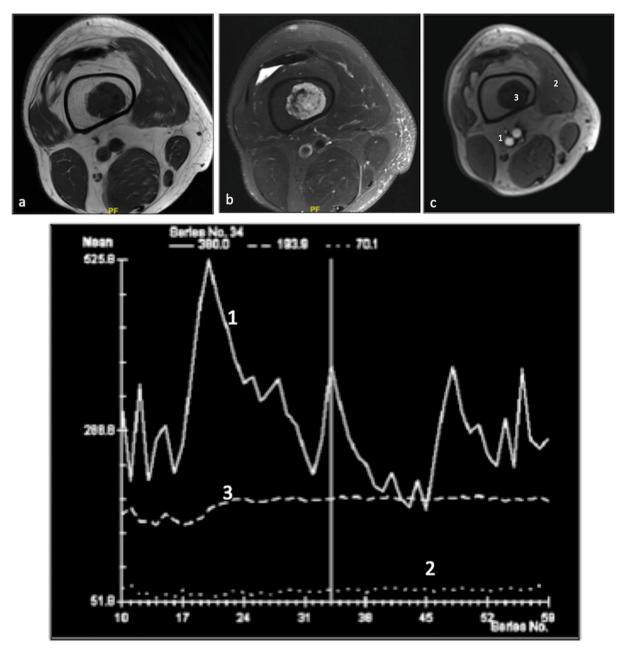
45 year old female with right knee pain. MRI axial T1 (a),T2FS (fat suppressed (b) and T1VIBE post contrast(c) with dynamic contrast enhanced imaging showing different enhancement curves for 1- artery, 2- muscle, 3- cartilage tumour.
